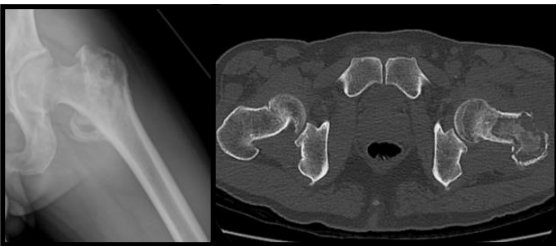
Radiograph and CT scan images.
